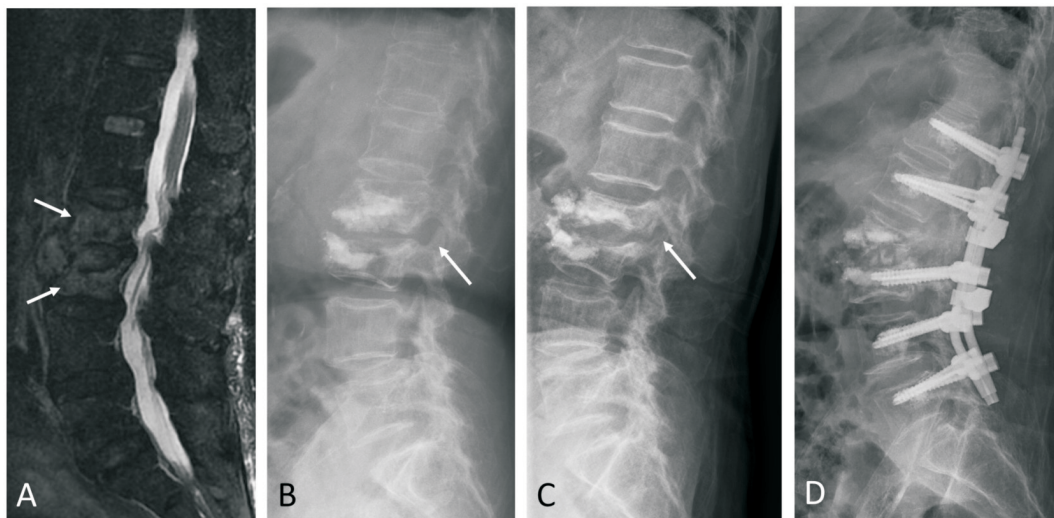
A 75-year-old female patient sustained motion related low back pain for one month. (A) MRI T2WI showed bone marrow edema in L2 and L3 (white arrow). (B) A lumbar spine lateral view one week after L2, 3 PKB. The size of L23 foramen was wide (white arrow). (C) Back pain recurred 6 months after the operation. A follow-up X-ray revealed re-collapse of the L23 cemented vertebra. The L23 foramen became narrowed (white arrow). (D) She underwent internal fixation finally.
